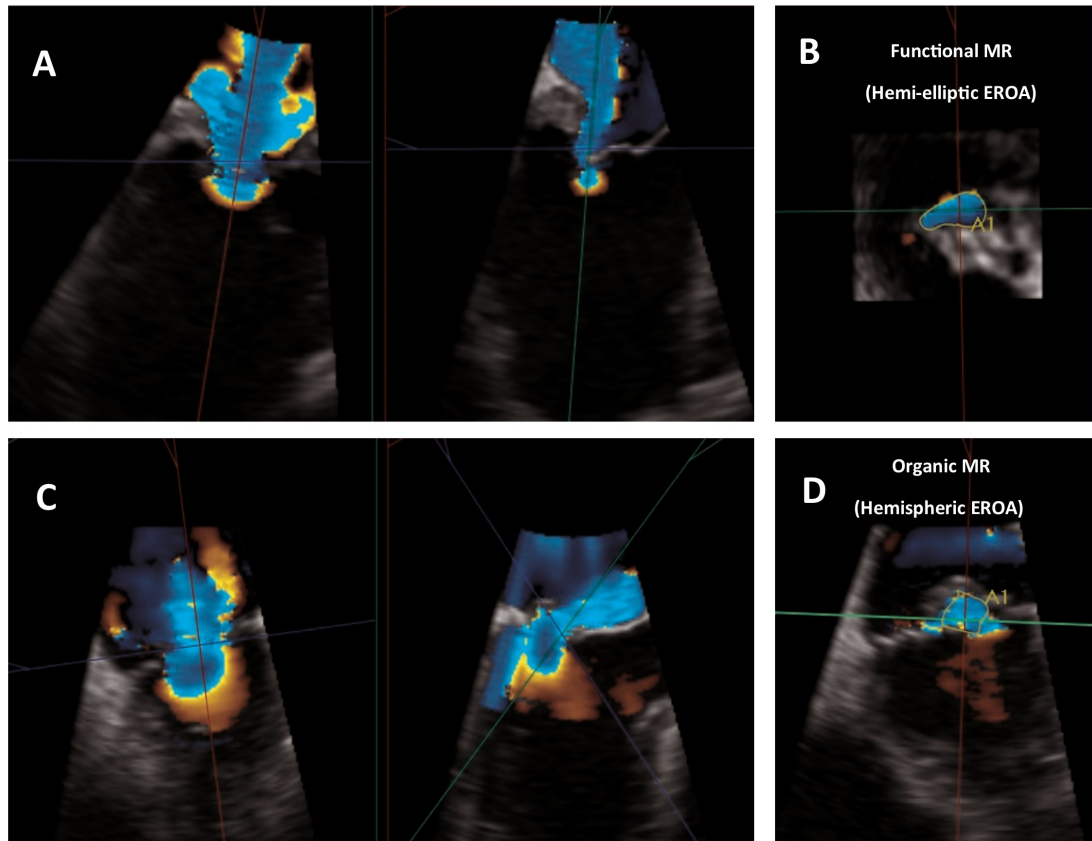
Two cases showing evaluation and quantitation of VC area with 3D echocardiography and multi-planar reconstruction
